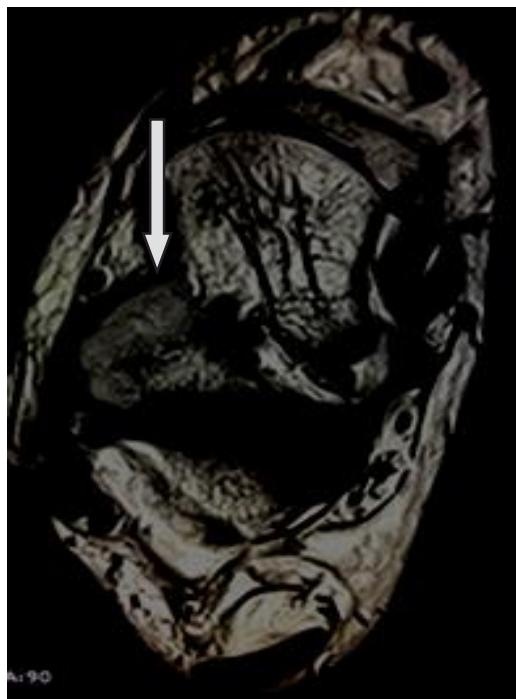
T2 Weighted MRI showing axial view of right ankle with intermediate signal intensity lesion at talus (white arrow)
